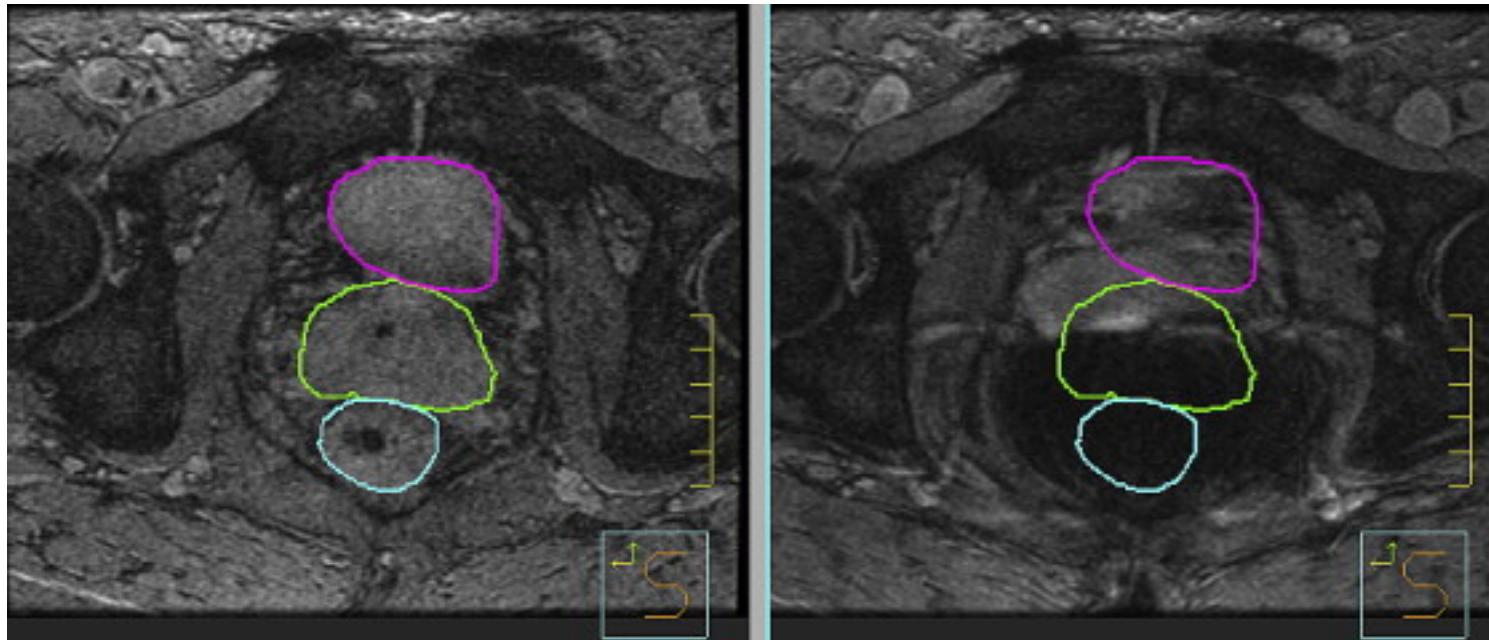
Repeat magnetic resonance images obtained for the example prostate patient. The bladder (pink), prostate (green), and rectum (blue) contoured on the first image (left) are overlaid onto the second magnetic resonance image (right) for reference.
